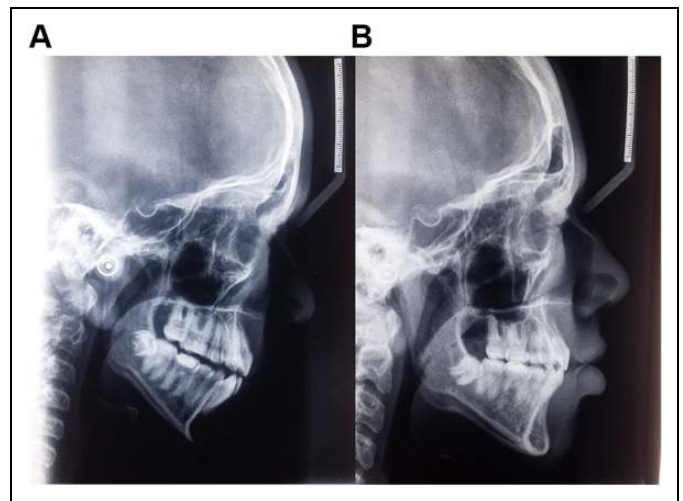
Lateral head radiograph: (A) before the orthodontic treatment, (B) after orthodontic treatment.
